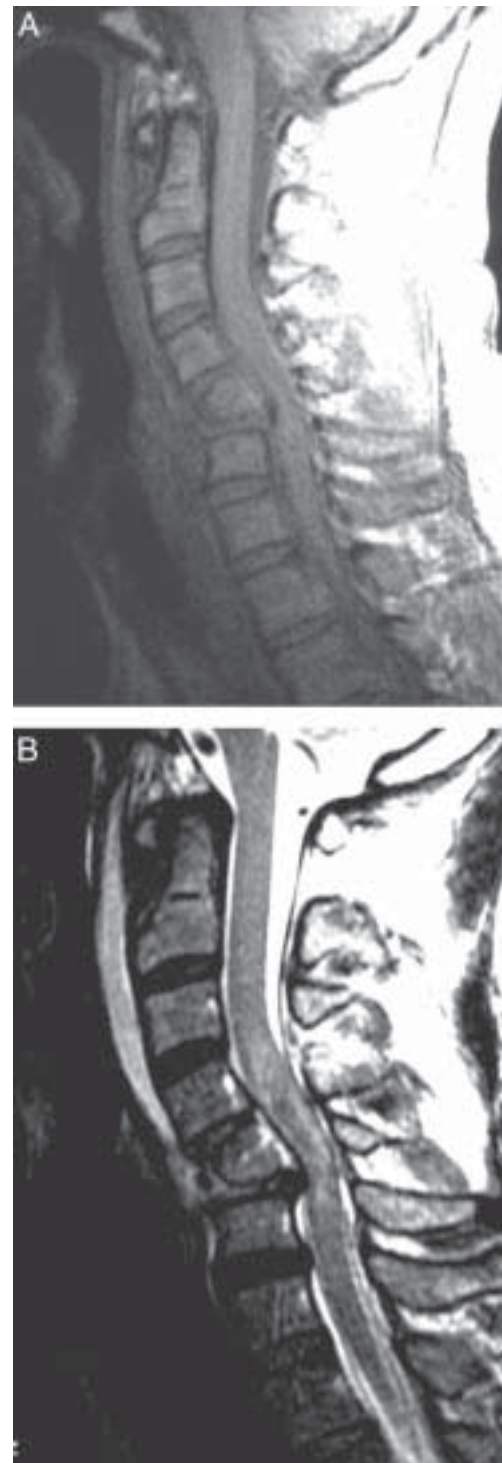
MRI at admission. T1-weighted image (A) showed no remarkable change, but T2-weighted image (B) showed a low-intensity area at the level of C5 that was surrounded by high-intensity area.
